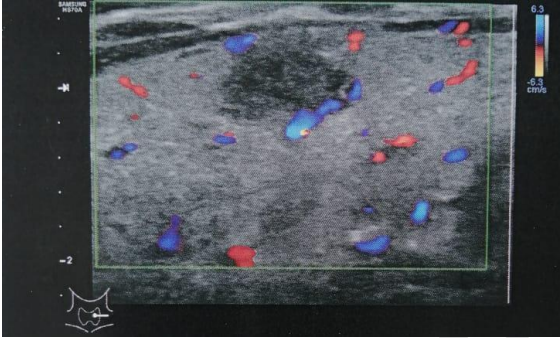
Doppler mode showing peripheral vascularization of the nodule
